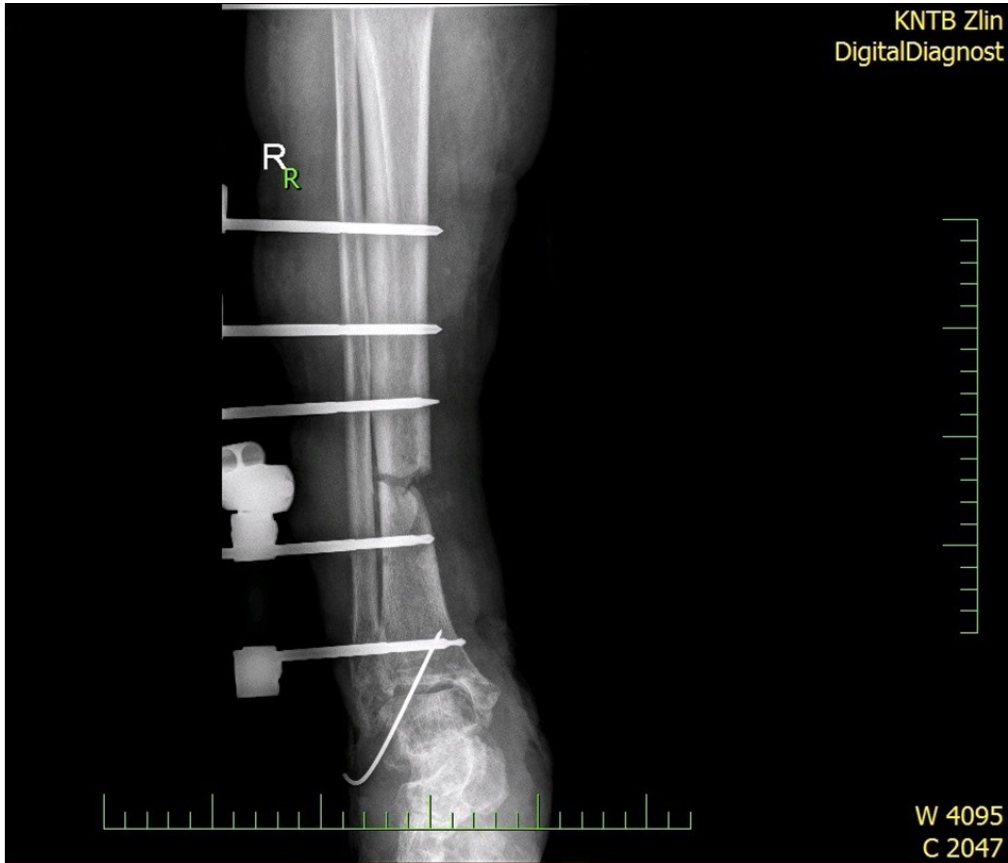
22 January – primary X-ray - Fracture stabilization using external fixator
